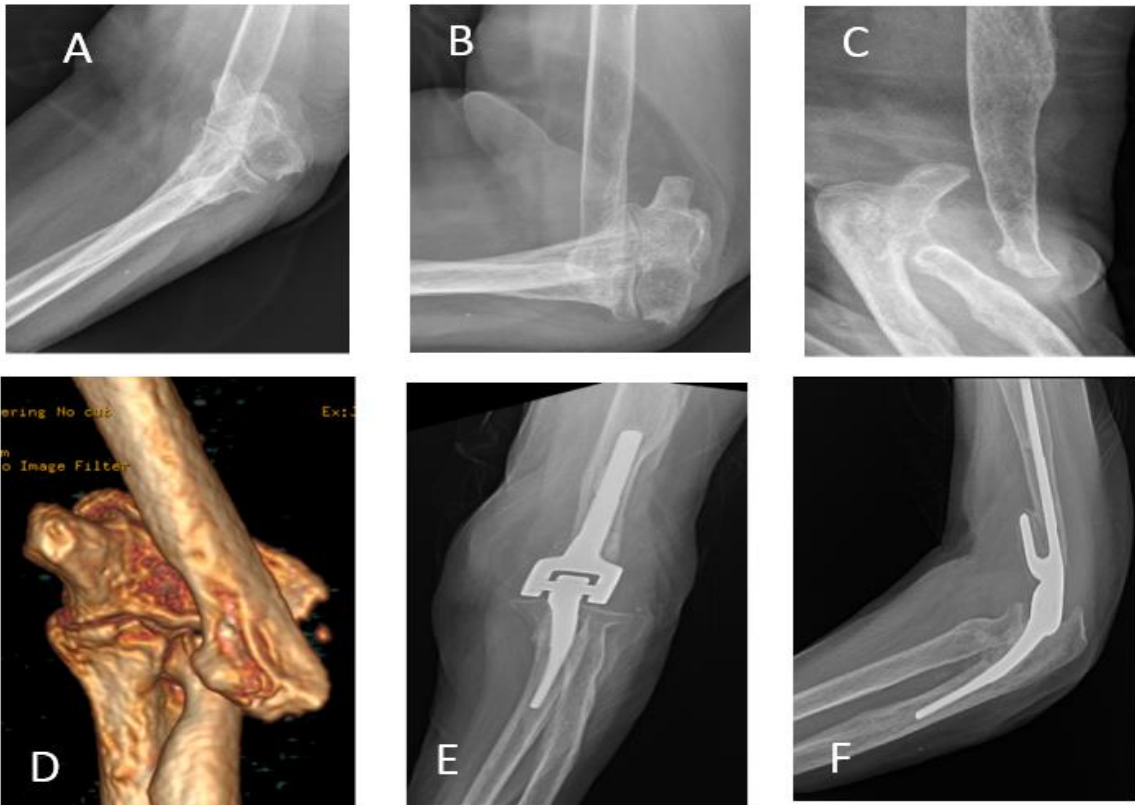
A 81-year-old female sustained a distal humerus fracture three years before. Due to medical comorbidities, surgical treatment was not possible at that time. She returned to the office with complaints of elbow instability, and therefore total elbow arthroplasty (TEA) was performed: (A-D) preoperative views; (E-F) postoperative radiographs
